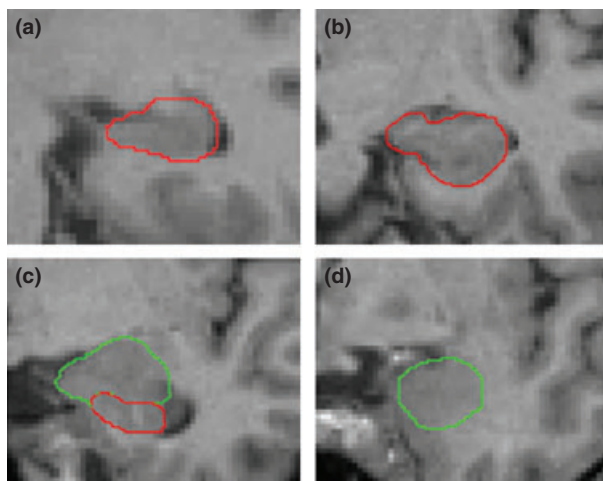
Example of hippocampal and amygdala measurement. Depicted are coronal MRI slices that run in occipito-rostral direction: (a) hippocampal body, (b) anterior part of the hippocampus, (c) posterior-medial part of the amygdala and (d) anterior-medial part of the amygdala. The whole volumes of the amygdala and hippocampus were determined by performing this procedure in all MRI slices in which the amygdala and hippocampus was visible.
